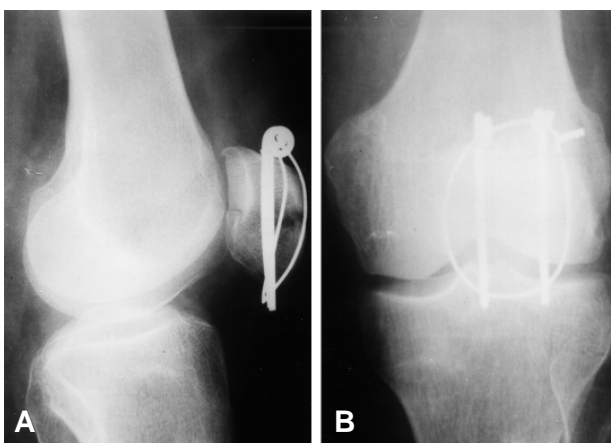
A, B Postoperative radiographs after fixation of fracture using self locking tension band technique
